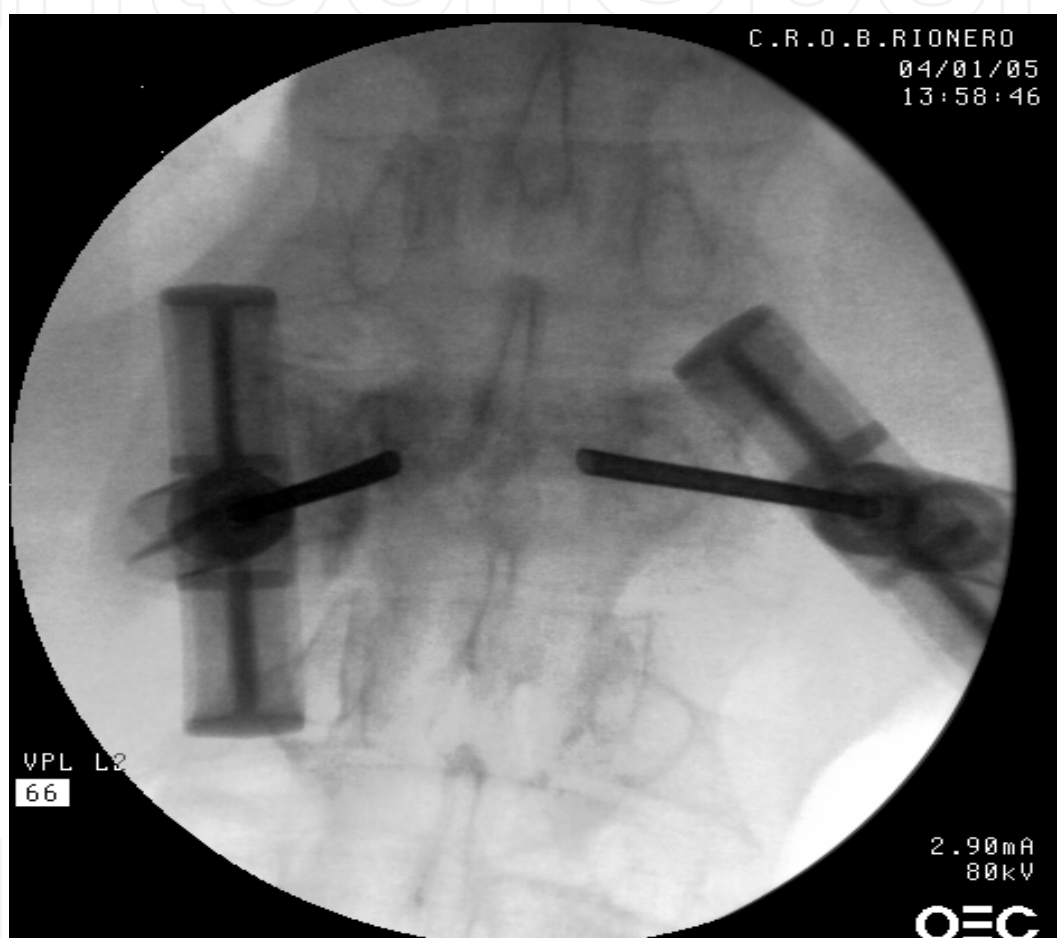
AP X-ray image of vertebroplasty
